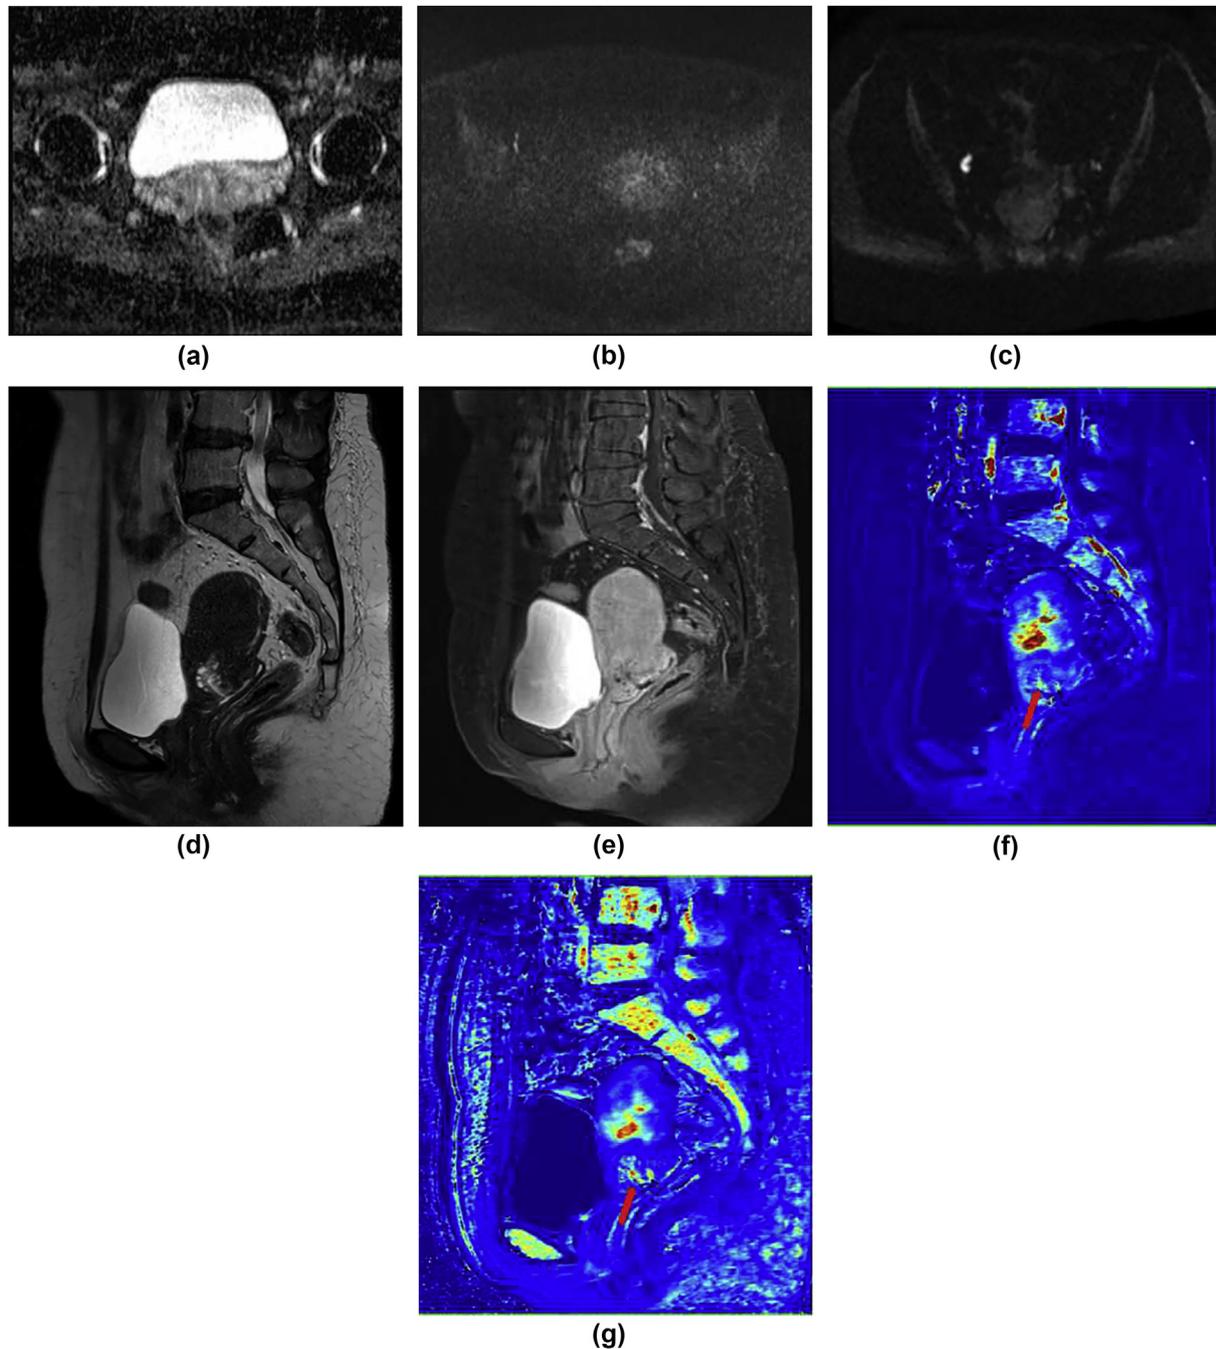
A 35-year-old woman with MRI-invisible residual cervical cancer but positive conisation pathology. (a) Axial DWI and (b) ADC map, (d) sagittal T2-weighted, and (e) contrast-enhanced images show no visible cancer. (c) Axial DWI shows a metastatic lymph node. (f) The colour-coded K^{trans} map and (g) K_{ep} map show that a heterogeneous abnormal intensity was identified.
